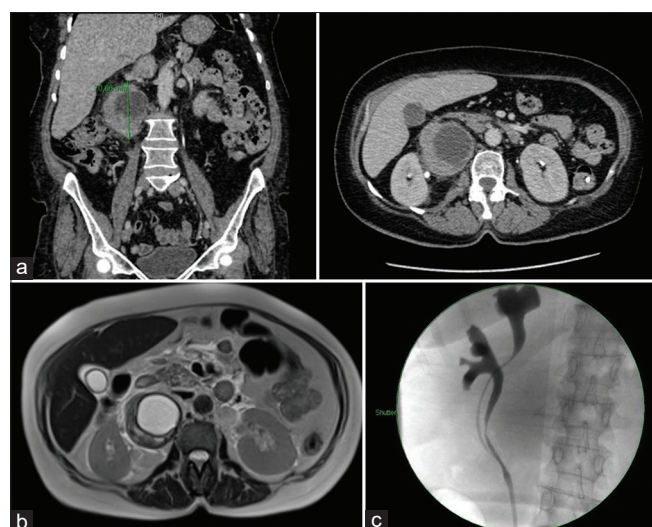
(a) Computed tomography scan showing axial and coronal views of the heterogeneously enhancing lesion measuring 7 cm. This image was taken in the excretory phase. (b) A coronal magnetic resonance imaging view showing the oval-shaped mass with a necrotic core, which appeared of low signal intensity on T1-weighted images and of low heterogeneous signal on T2-weighted images and shows enhancement of the solid component. (c) Retrograde pyelogram showing a duplex right collecting system fused at the mid ureter
